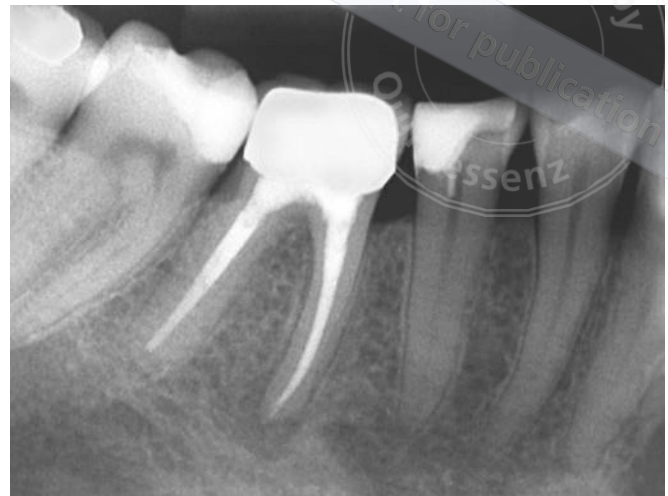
X-ray after root canal filling and adhesive closure of the access cavity. The picture for the radiographic follow-up examination after 1 year was not available at the time of the completion of this article.
